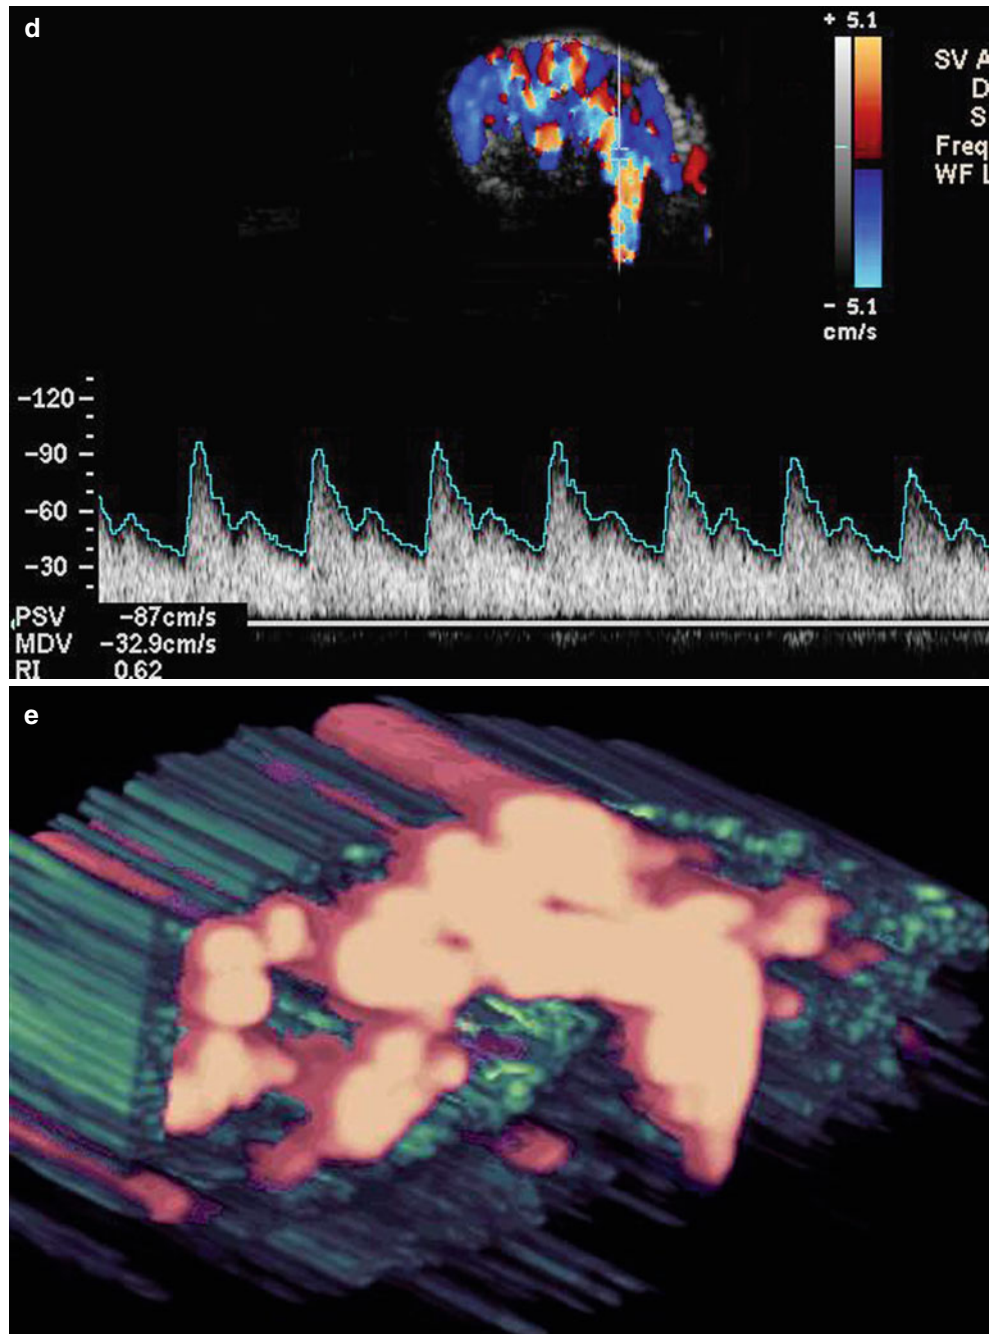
(a–e) High-flow arterial vascular malformation. (a) Clinical lesion shows erythematous swelling in the helix of the left ear pinna. (b) Grey scale ultrasound image (transverse view) demonstrates multiple anechoic tubules (*) affecting the dermis and part of the auricular cartilage.
